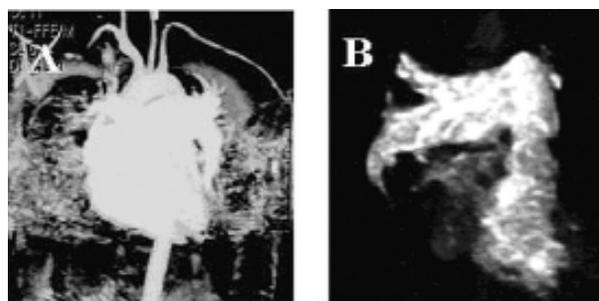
Case 4: Magnetic resonance imaging (MRI)– A– Pulmonary artery diameter two times bigger than aorta diameter; B- Pulmonary artery left branch with suggestive images of organized thrombi.
